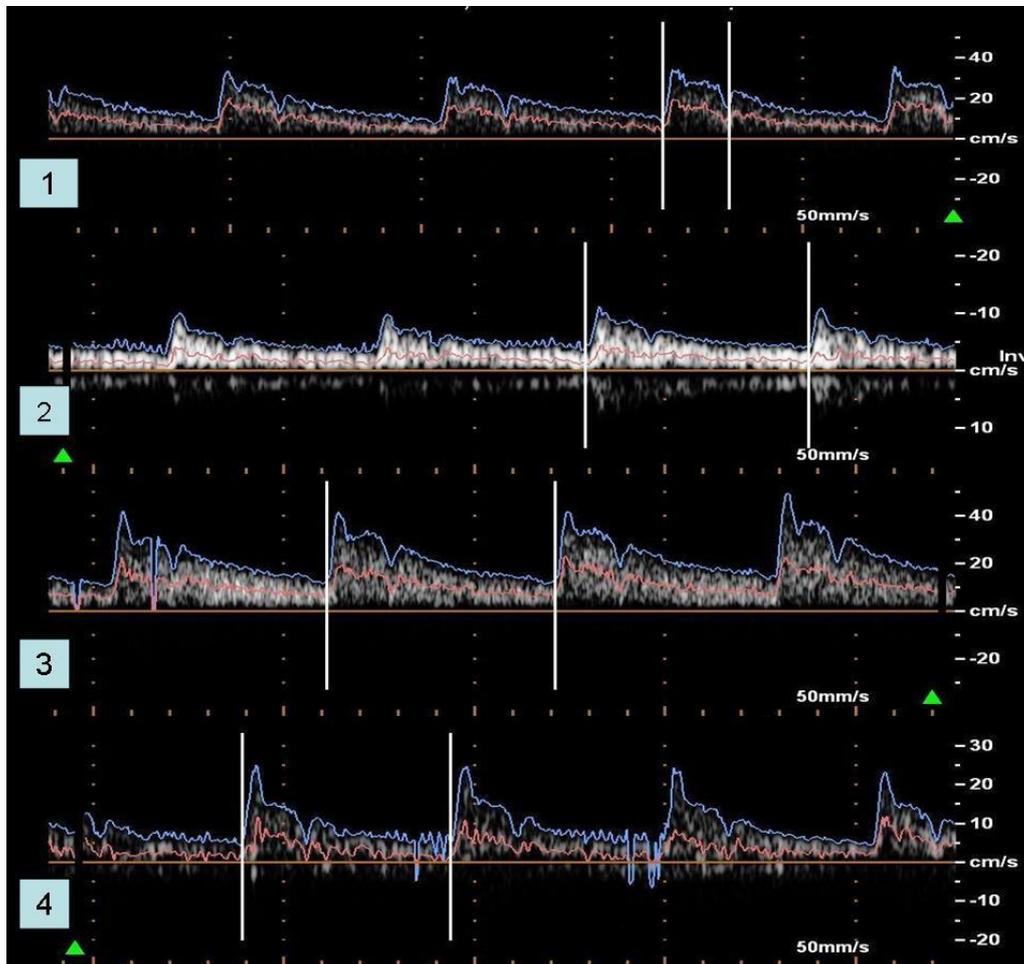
Duplex sonography of tooth pulp 1 hour (1), 1 day (2,) 3 days (3), and 20 days (4) after the start of the experiment. 1 – an expressed venous wave on the descending curve; 2 – a reduced amplitude, an increased vessel tone, and a weak venous wave; 3 - increase in amplitude, a slightly expressed venous wave; 4 - a reduced amplitude, a sharply increased vascular tone
